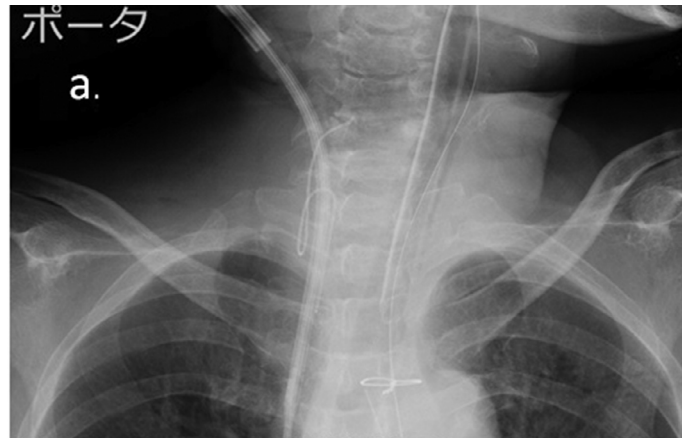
Chest radiograph taken after surgery showed a fractured guidewire near the right internal jugular vein.
